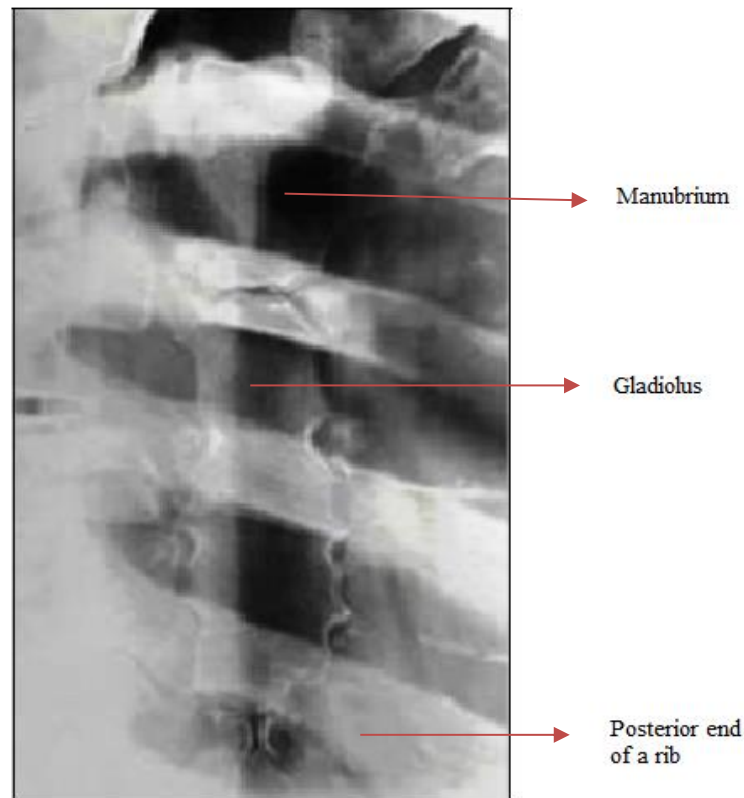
A section of the right anterior oblique view of the chest x-ray to demonstrate the coronal view of the sternum from behind. The image has been modified to enhance its appearance for clarity. The problem of altered grey-level values of the sternum due to the overlapping of other tissues to calculate the real tissue attenuation density of the sternum is obvious in a multilayered image like that of the thorax. (Source - xrayandradiologylecturenotes.blogspot.com/2012/12/sternum-clavicle-ribs.html).
